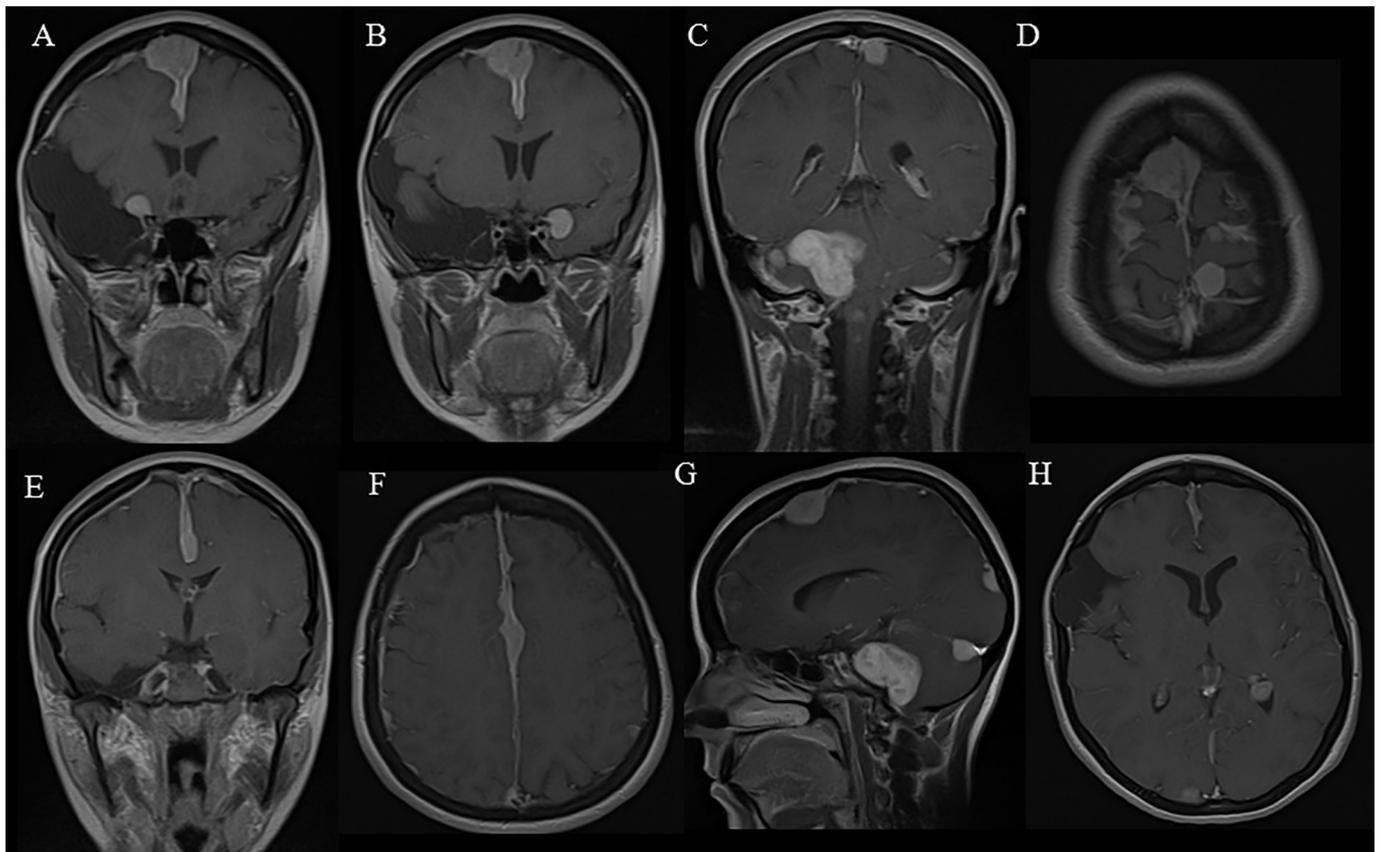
MRI, T1 + Gd: Brain meningiomatosis in a patient with NF2. (A, B) Bilateral meningiomas in the anterior clinoid process and right-sided parasagittal meningioma. (C) Left-sided parasagittal meningioma. (D) Convexital meningiomatosis. Nodular mass lesions, non-uniform thickening and contrast accumulation in the convexital dura mater. (E, F) Thickened cerebral falx. (G) Right-sided parasagittal meningioma in the occipital region and right-sided infratentorial meningioma. (H) Meningioma in the posterior horn of the left lateral ventricle.
